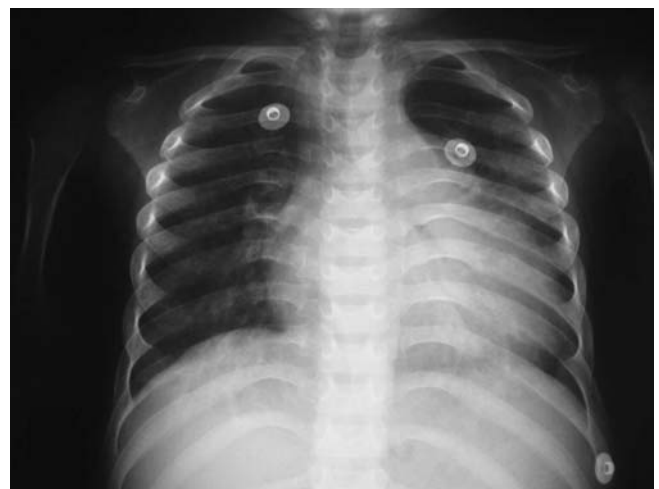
Cardiomegaly on chest X-ray
